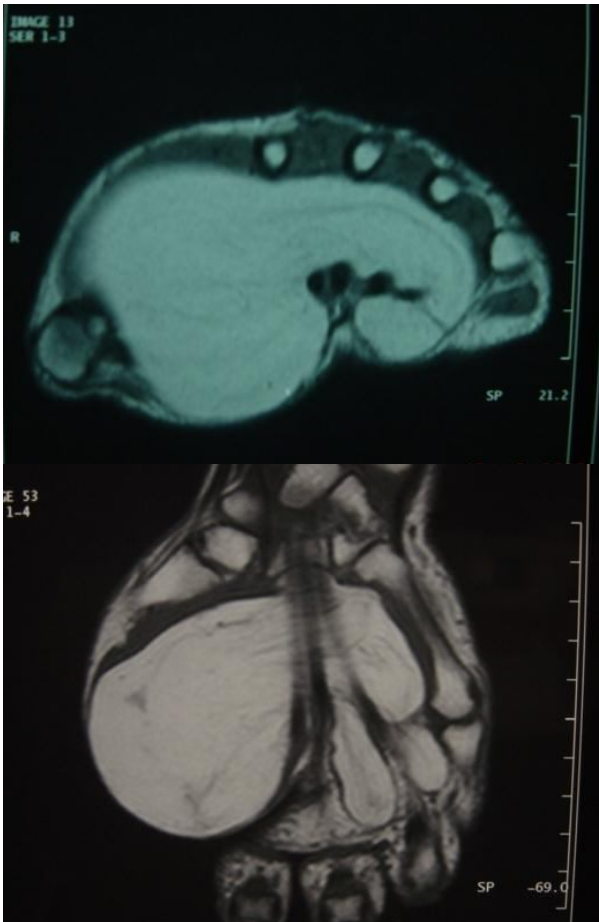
MRI : typical appearance of a lipoma extending to the entire palm of the hand
